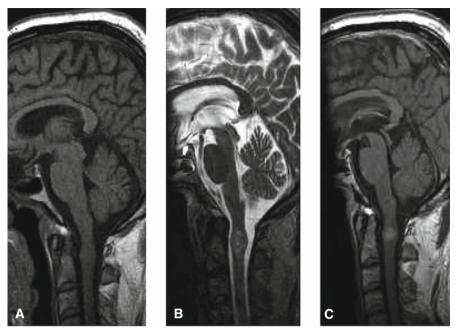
C2 ependymoma pre-operative MRI. A T1Wi, B T2Wi, C Gadolinium T1Wi
